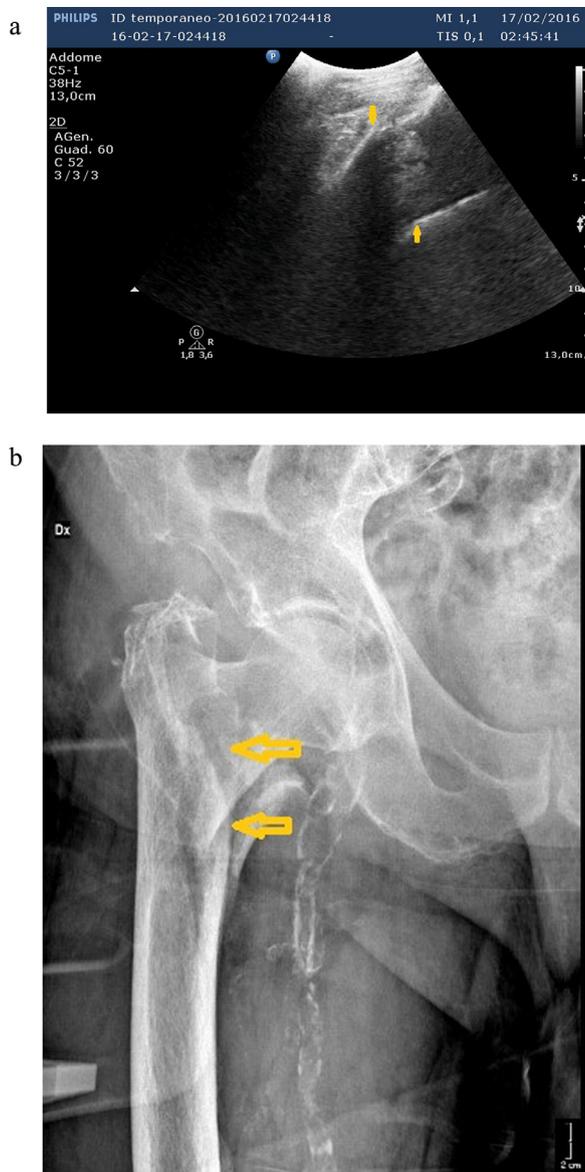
(a) Ultrasound imaging of a femur fracture. *Yellow arrows* point to bones out of place at the joint connecting them. (b) X-Ray image of a femur fracture. *Yellow arrows* point to bones out of place at the joint connecting them.
